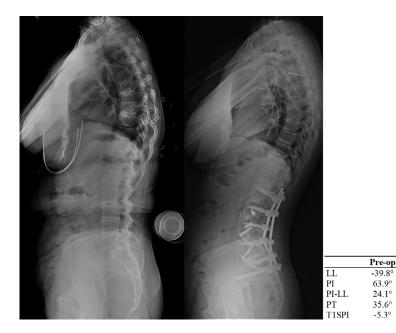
Preoperative (left) and last (2-yr) postoperative (right) standing lateral radiographs of a 68-year-old female who underwent L2-S1 anterior column realignment via L2-L4 LLIF ACR and L4-S1 ALIF ACR, with percutaneous posterior fixation L2-Ileum. Short-segment approach in this patient resulted in improved and harmonious lumbar lordosis and corrected overall standing alignment. LL = lumbar lordosis; PI = pelvic incidence; PI-LL = pelvic incidence lumbar lordosis mismatch; PT = pelvic tilt; T1SPI = T1 spinopelvic inclination.
